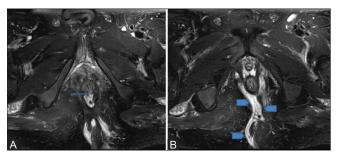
(A and B): (A, B) Axial fat-suppressed T2-weighted images of the pelvis showing a linear transsphincteric fistula at the 6 o' clock position of the anal canal (arrow in A). Multiple T2 hyperintense fluid filled intercommunicating tracts are seen extending in a horseshoe shaped configuration around the anal canal (arrow heads in B)
